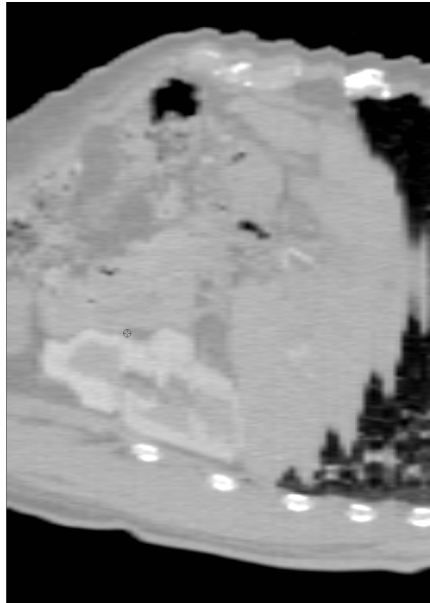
Respiration-related imaging artifacts in a sagittal reconstructed CT image, clearly affecting the shape of the diaphragmatic dome.*
